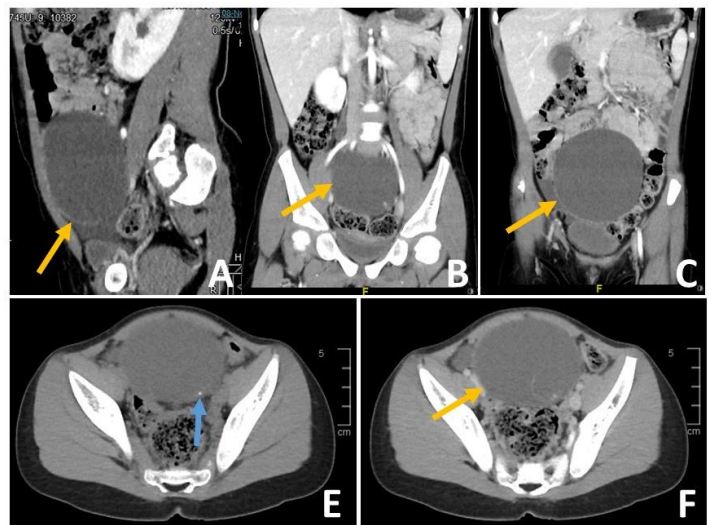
CT scan of the patient showing the abdominal mass (Orange arrow) with eccentric calcification (Blue arrow): A: Sagittal view (Contrast), B: Coronal view (Contrast), C: Coronal view (Contrast), D: Transverse view (Plain), E: Transverse view (Contrast)
